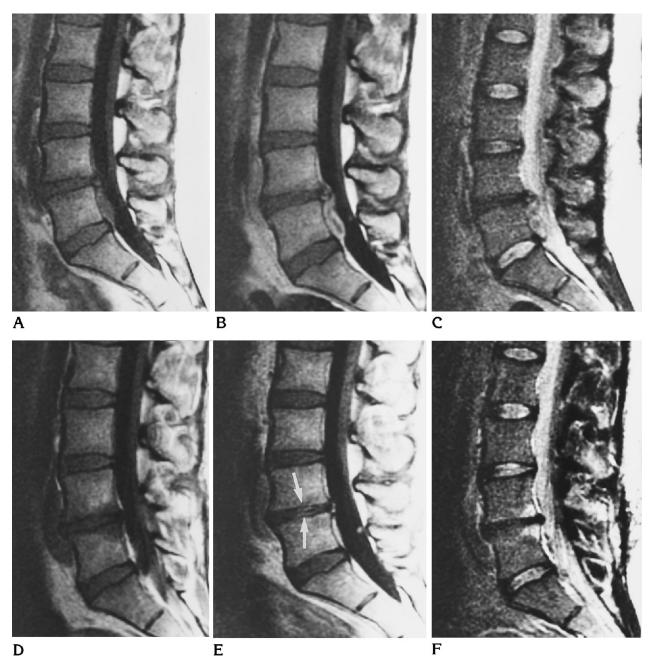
A-C, Preoperative sagittal T1-weighted images before (A) and after (B) administration of contrast material show a large free fragment extending from the L4–5 intervertebral disk with inferior migration behind the L-5 body. There is a moderate amount of surrounding enhancement. The T2-weighted image (C) shows decreased signal from the L4–5 disk space, and heterogeneous signal from the disk fragment.
